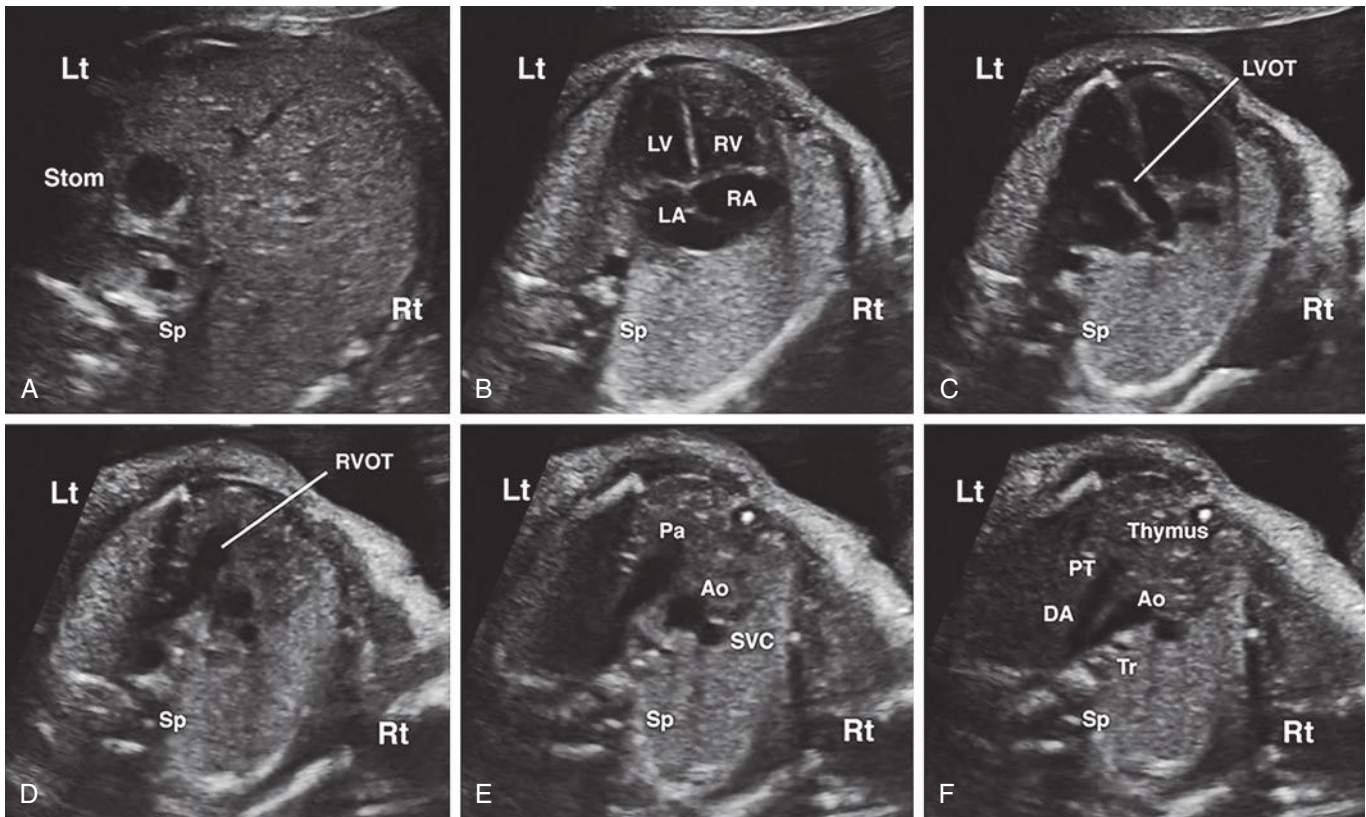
Standard ultrasound scanning planes are used to evaluate the fetal heart by evaluating the following: A, abdominal situs; B, four-chamber view; C, left ventricular outflow tract; D, right ventricular outflow tract; E, three-vessel view; and F, three-vessel and trachea view. Ao, ascending aorta; DA, ductus arteriosus; LA, left atrium; Lt, left; LV, left ventricle; LVOT, left ventricular outflow tract; Pa, pulmonary artery; PT, pulmonary artery trunk; RA, right atrium; Rt, right; RV, right ventricle; RVOT, right ventricular outflow tract; Sp, spine; Stom, stomach; SVC, right superior vena cava; Tr, trachea.
